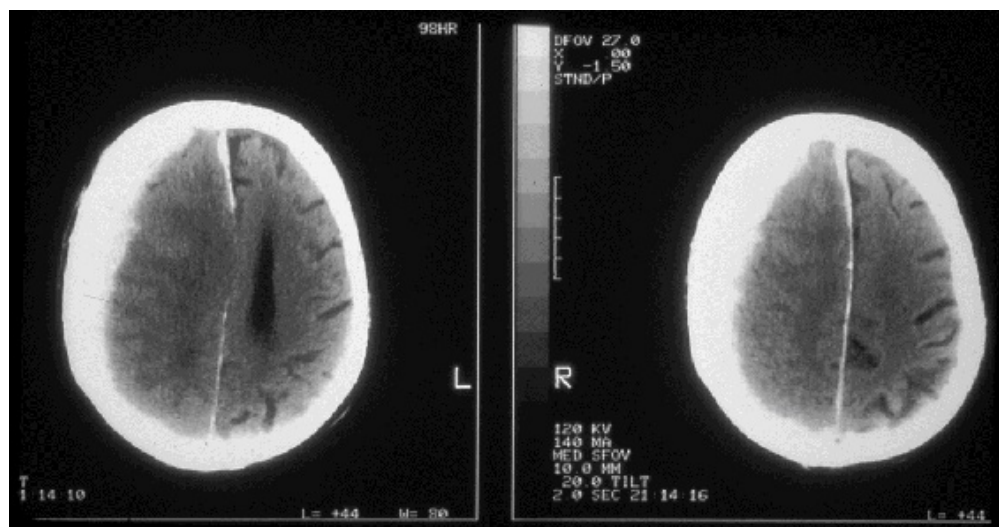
CT Scan Demonstrating Subdural Hematoma with a
